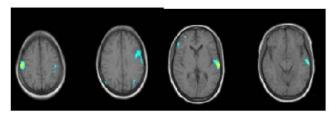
5 "Lit-up" example of function MRI brain analysis.
